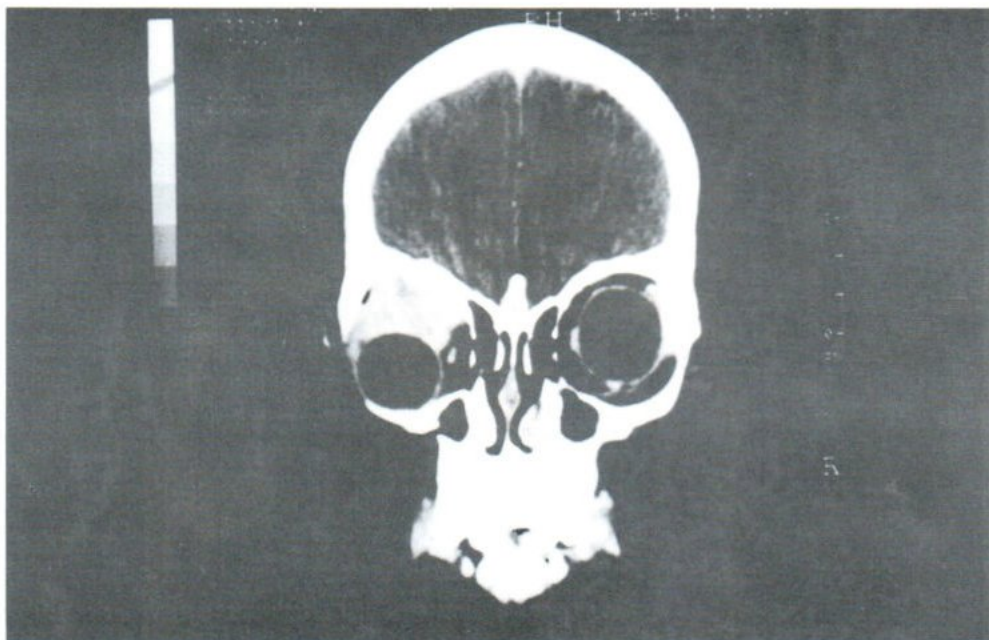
Rhabdomyosarcoma: Coronal CT scan shows homogeneous enhanced left orbital mass.
